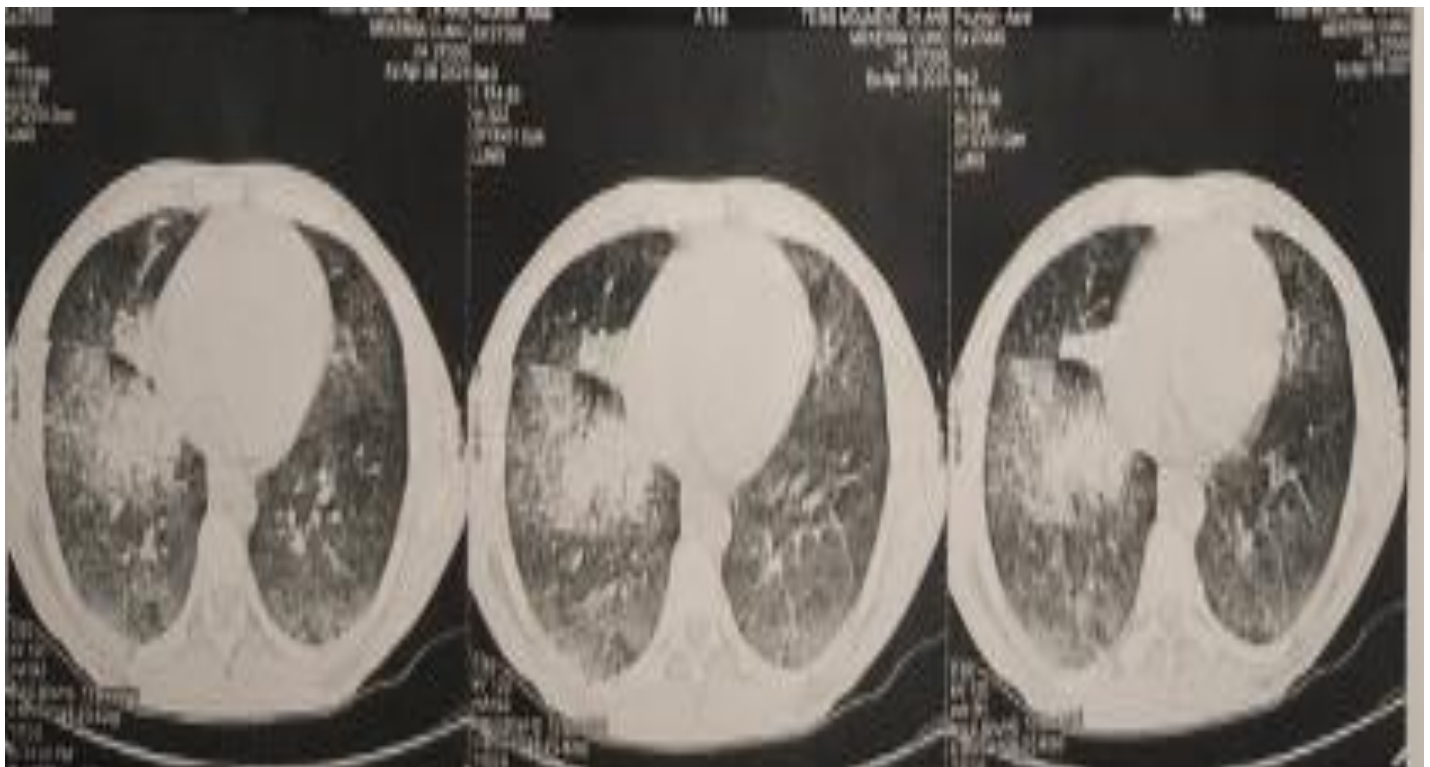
Thoracic CT: polished glass appearance of bilateral lung fields suggesting intra-alveolar hemorrhage
